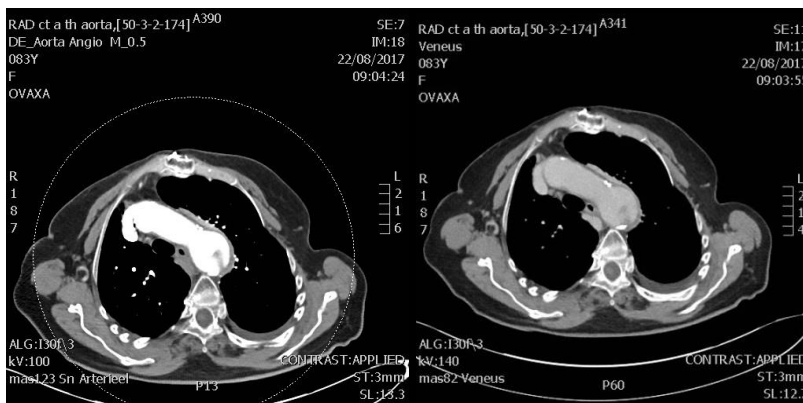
Computed tomography and TEE revealed focal ectasia in the wall of the aortic arch (about 3.5 cm distal to the left subclavian artery) with a type B aortic dissection characterized by an interruption of the intima over a length of 27 mm and formation of a false lumen with a length of 39 mm and a thickness of 17 mm.
